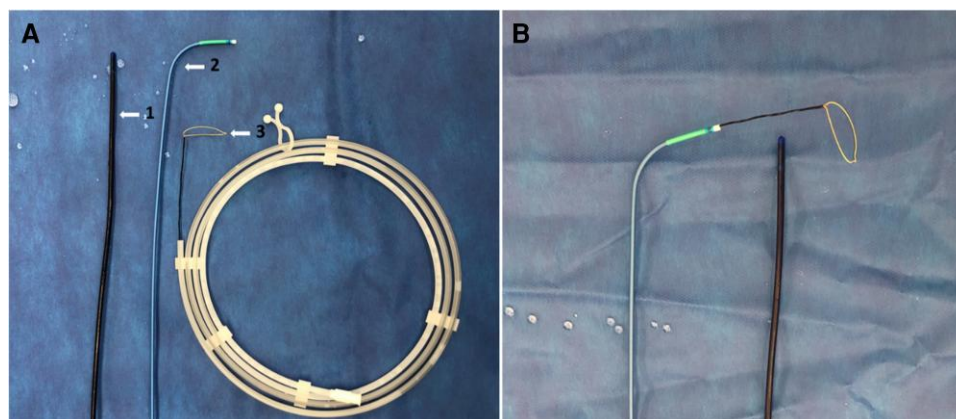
(A) 1. 10 French AcuNav ultrasound catheter, 2. 7 French multipurpose guide catheter, 3. 25 mm ev3 Amplatz GooseNeck snare. (B) ev3 Amplatz GooseNeck snare inside a 7 French multipurpose guide before introducing the guide into the 16 French Check-Flo introducer over a ProTrack wire.
